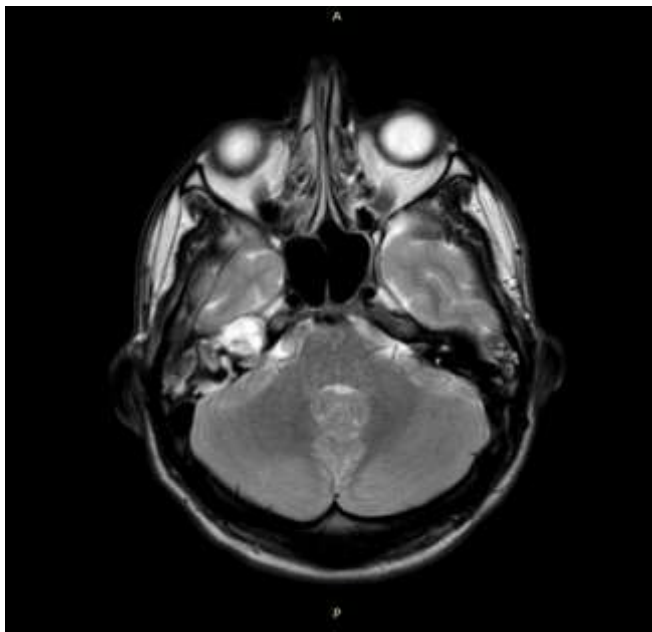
Axial MRI brain T2W-TSE image for patient number 9 shows Cholesteatoma and mild left mastoiditis.
